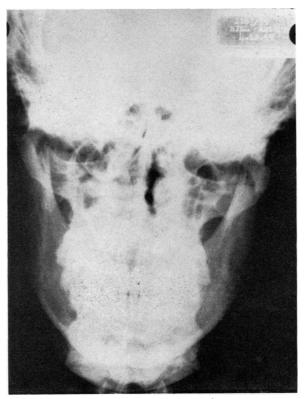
P.A. X-ray showing position of condylar head.
